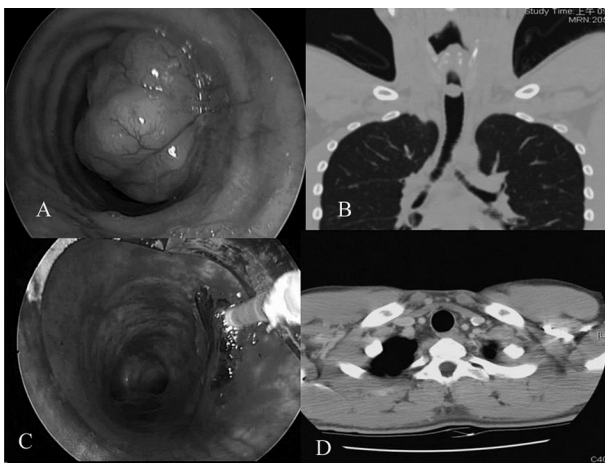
Endoluminal tumor (cystic adenoid carcinoma) with severe tracheal stenosis: A,B. Preoperative bronchoscopy and CT finding. C. Intraoperative bronchoscopy finding after coring out procedure. D. Postoperative CT image.
